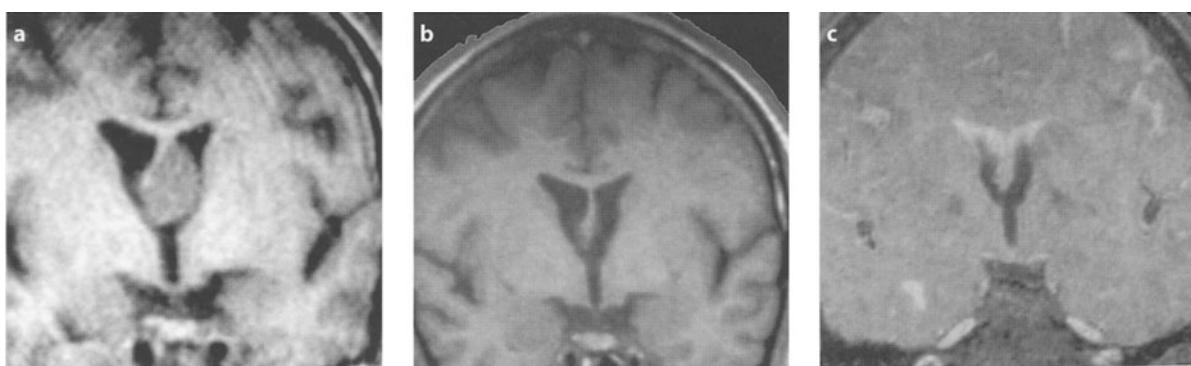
a Preoperative MRI (coronal view) of a colloid cyst that developed mainly in the left lateral ventricle. b Coronal T2-weighted MRI 1.5 years postoperatively show that no remnant can be observed. c Coronal MRI flow sequence (FISP) shows both foramina of Monro to be free of any obstruction
